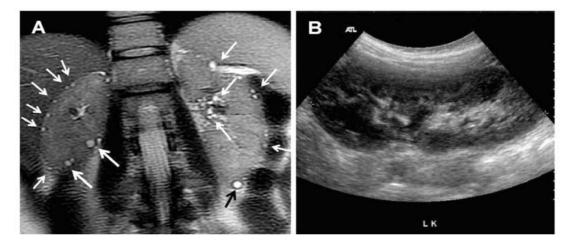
T2 weighted breath-held MRI showing multiple tiny cysts in a cortical and perihilar distribution (white arrows)
